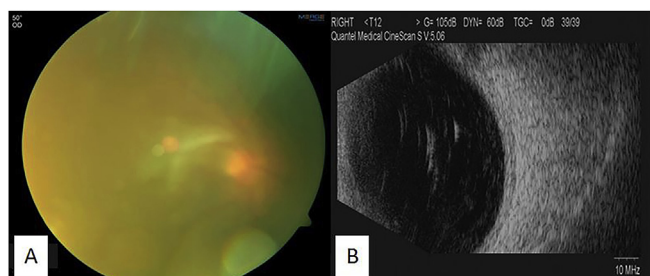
Clinical and ultrasound findings at the first presentation showed a complete involvement of the posterior segment, Visual acuity 20/200; A. Vitreous haze and impaired fundus view, B. B-scan: dense vitreous opacities.
